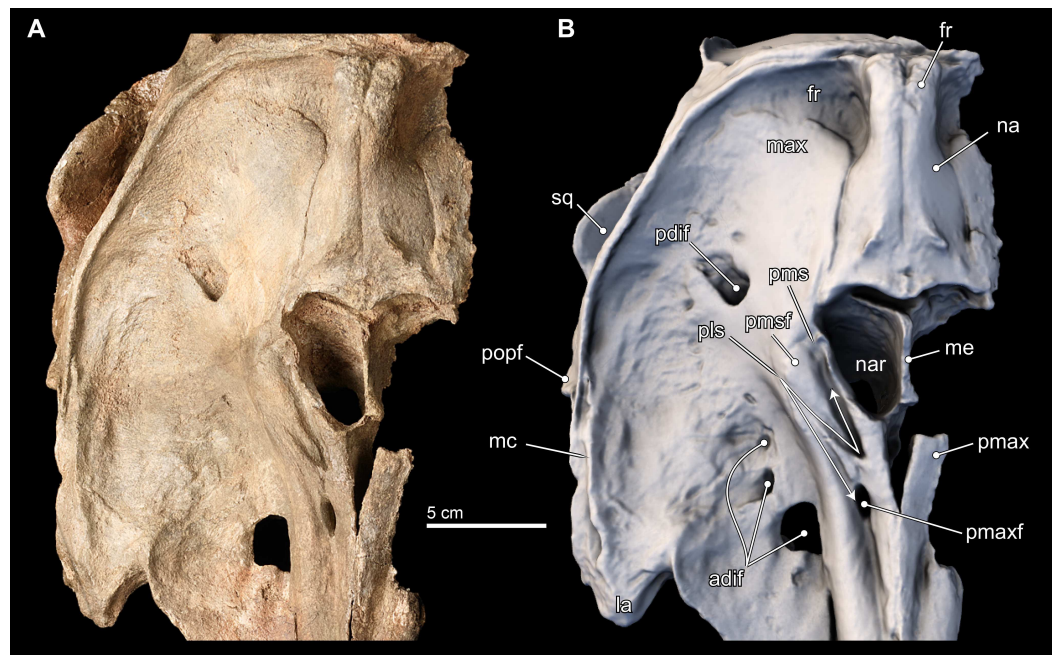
Close-up on vertex of skull. Close-up views of the vertex in the type skull of *Isthminia panamensis* (USNM 546125) from (A) photographs and (B) orthogonal digital three-dimensional polygon model prepared from CT data, with lighting and color modifications using the Smithsonian X 3D browser. See <http://3d.si.edu/explorer?s=cGDc1L> to measure, modify, or download this model.
